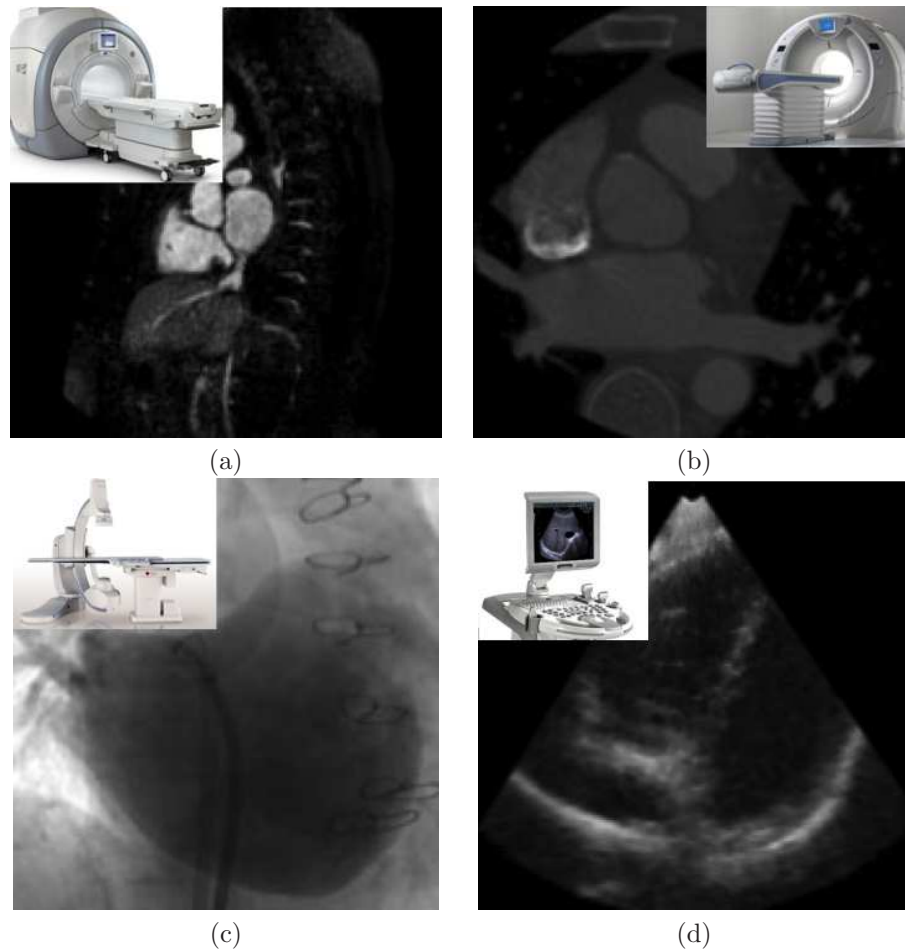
Examples of pre-procedural imaging: top left: contrast-enhanced 3D steady-state-free-precession MR image; top right: prospectively-gated, contrast-enhanced CT image; bottom left: rotational X-ray angiography of left atrium; bottom right: live 3D ultrasound. Reproduced with permission from [60]. Copyright IEEE.
